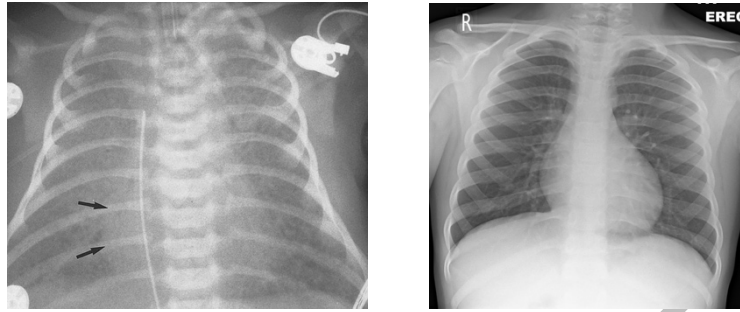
Traditional chest radiograph of hypoplastic left heart syndrome displaying right sided hypertrophy, left sided hypotrophy, and pulmonary reorganization (left) compared to normal anatomy (right).
